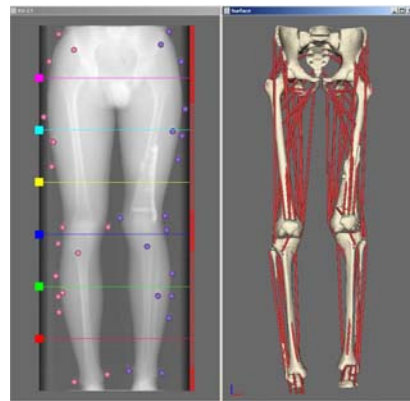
CT (left) and the derived muscle-skeletal model (right)
